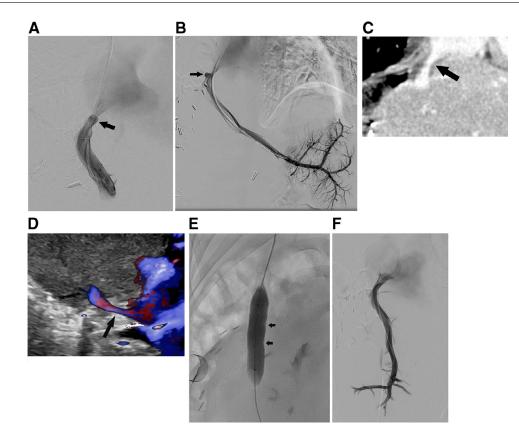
Hepatic venogram at 8 weeks (a) and 12 weeks (b) after the use of drug-coated balloons, showing recurrence of the restenosis, however, patency was preserved and the dilatation of the hepatic vein in (b) was less significant than in previous procedures. A small focal sacular dilatation was noted (arrow) which was not visible in subsequent treatments. (c) CT and (d) Ultrasound showed similar findings during the course of the treatments with patency at the area of stenosis (arrow). (e) Use of a 12 mm diameter-4 cm long drug-coated balloon in the last hepatic vein dilatation. The balloon showed mild indentations at the area of stenosis (arrows). (f) Satisfactory venographic result was obtained. The patient remained asymptomatic until there was invasion of the vein by recurrence of the primary disease.
